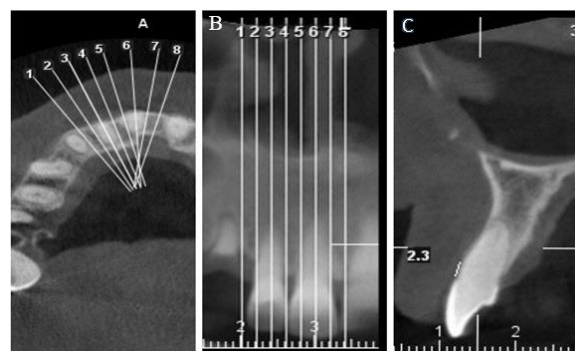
(A) Axial view; (B) Mesiodistal dimension was bisected on panoramic view to find the mid-buccal point; (C) Cross-sectional view of the CBCT image used to measure the distance from the CEJ to the buccal bone crest.
